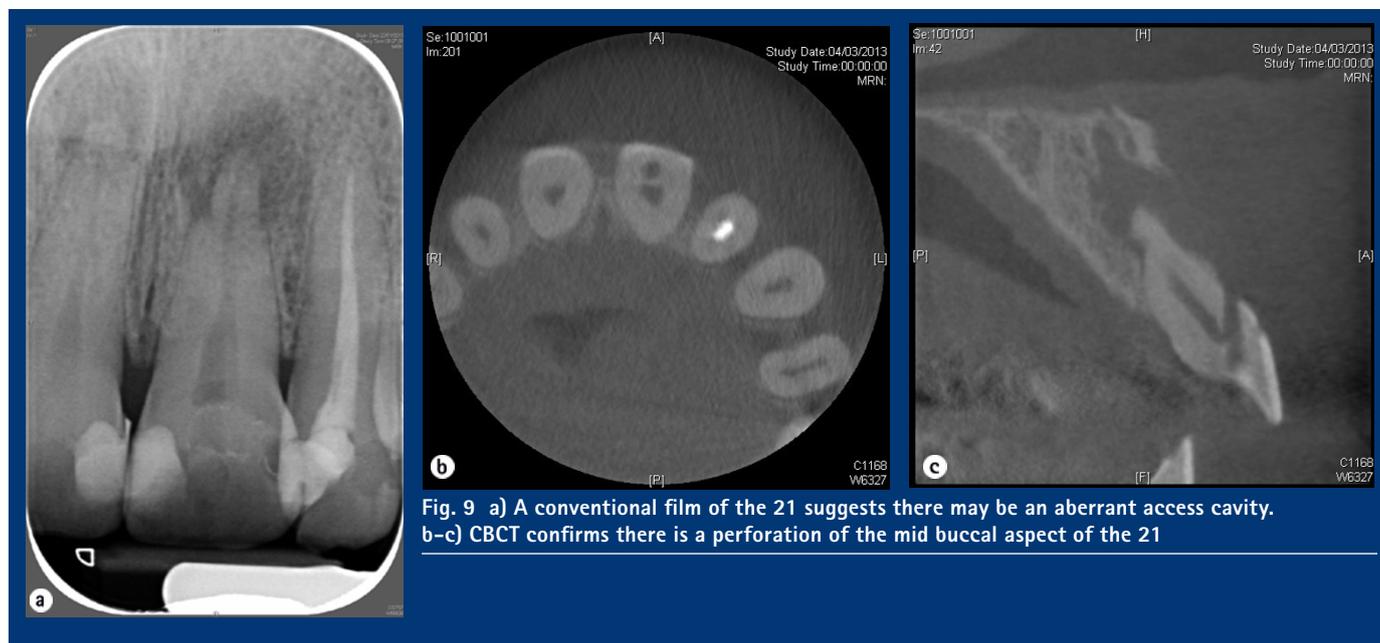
a) A conventional film of the 21 suggests there may be an aberrant access cavity. b-c) CBCT confirms there is a perforation of the mid buccal aspect of the 21
